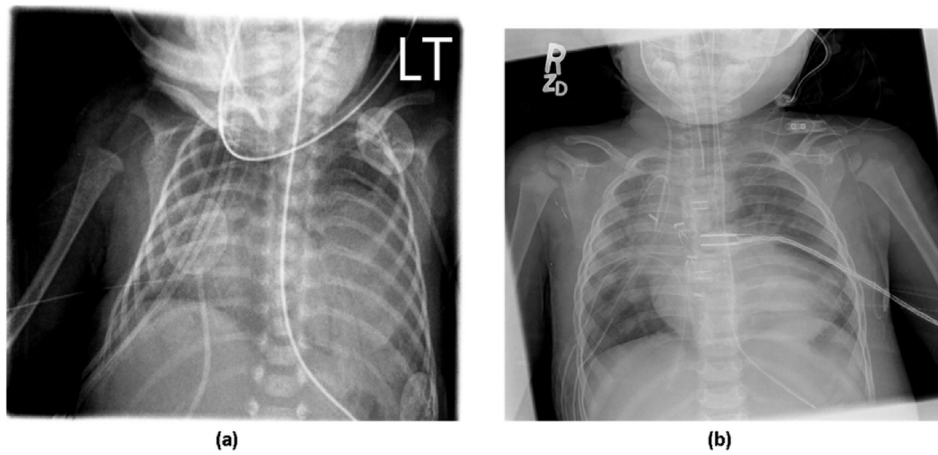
Pediatric chest radiographs demonstrating readers decision (a) to repeat and (b) do not repeat.
